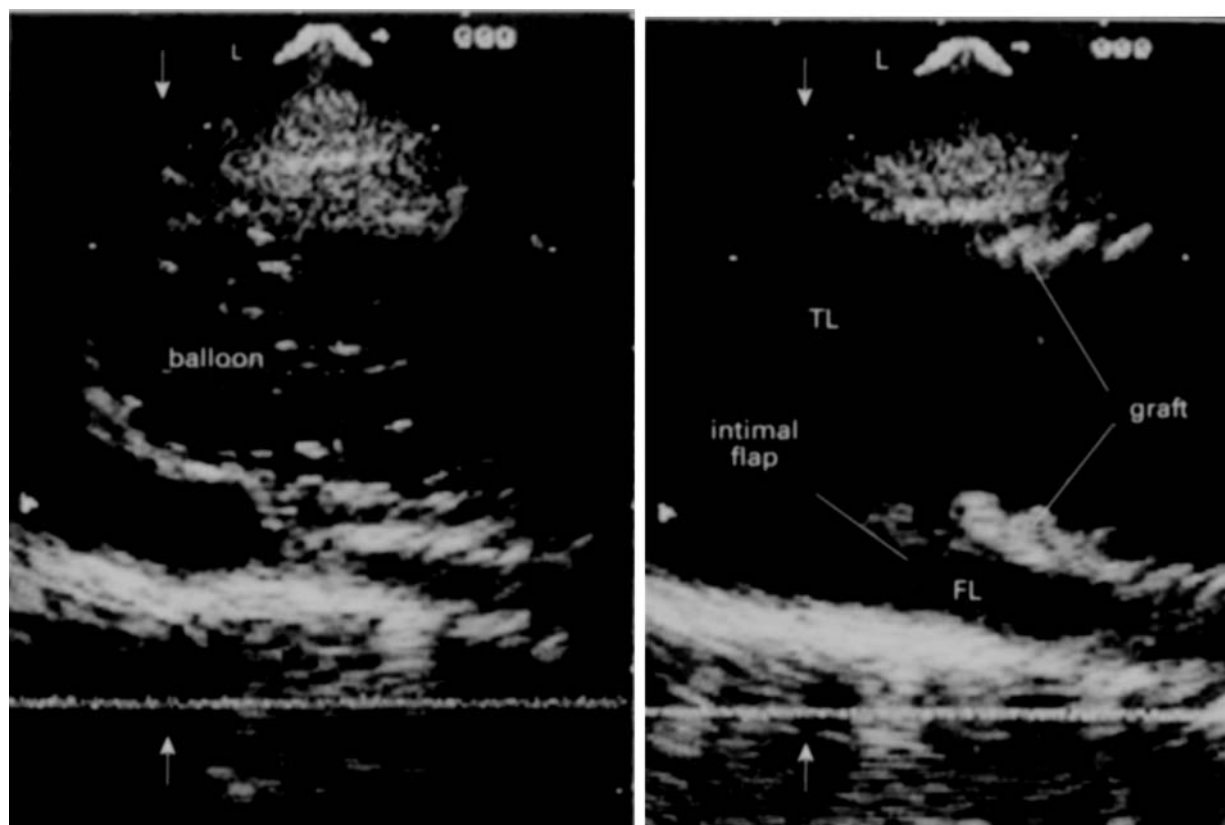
Transoesophageal echocardiogram showing placement of an aortic graft incorporated with self-expandable stent in a case of aortic dissection. The graft fills the true lumen (TL). FL = false lumen.
